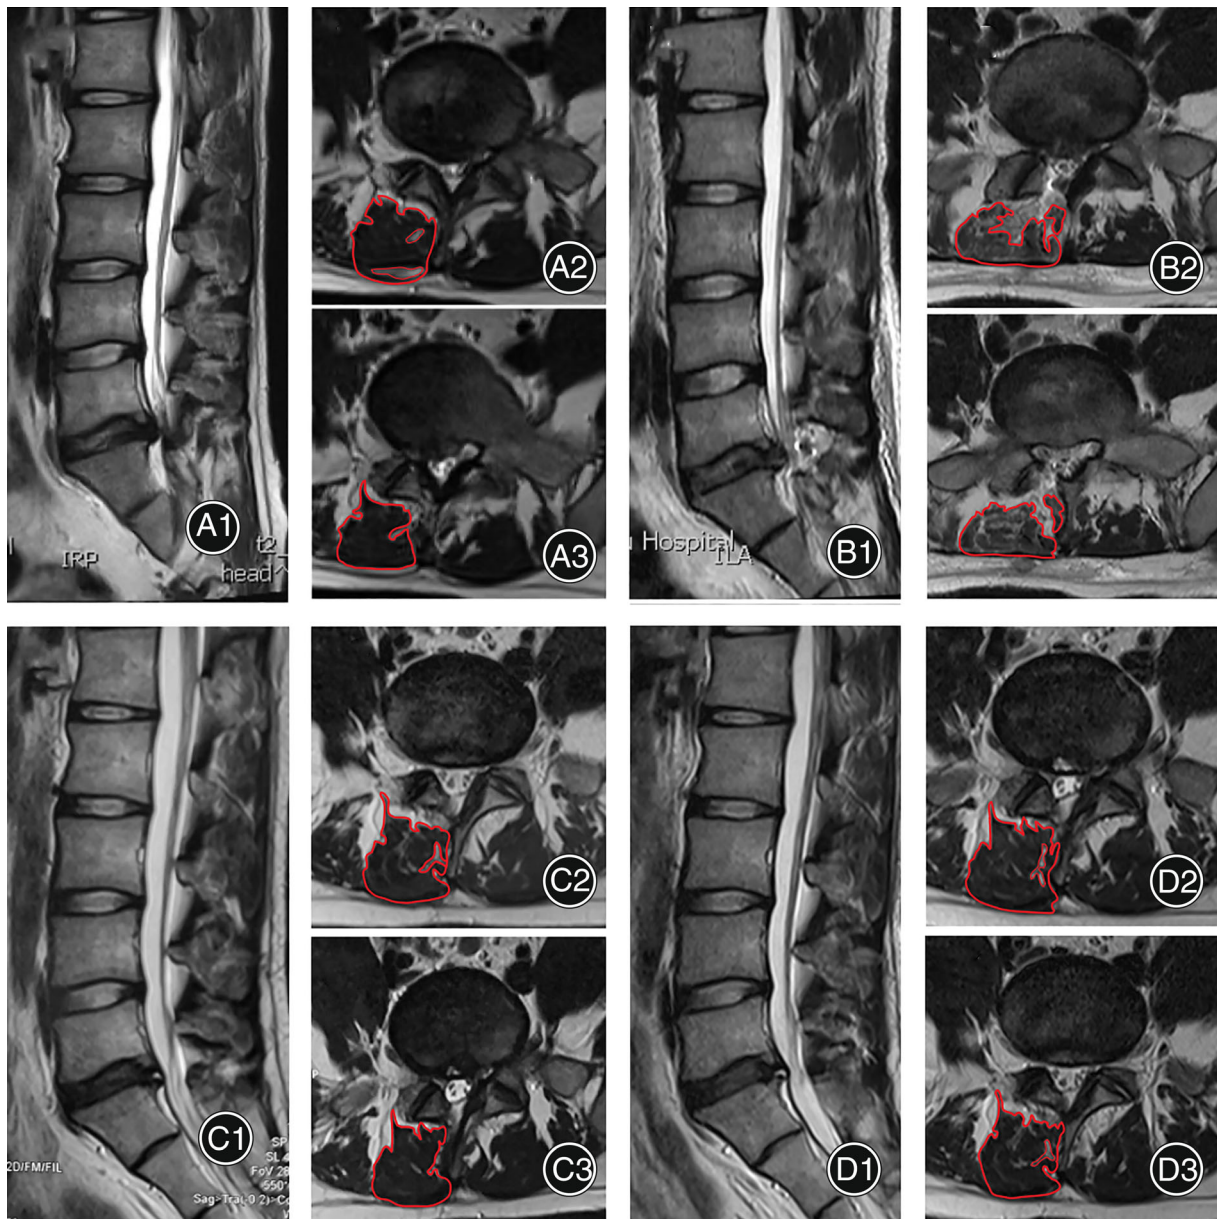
A 23-year-old male patient with LDH of L5/S1 right side, treated with UBED surgery. A1-A3 were the preoperative MRI. B1-B3 were the MRI of post-operative 1st day. C1-C3 were the MRI at the 3-month follow-up. D1-D3 were the MRI at the last follow-up of 1-year. The figures showed that the protruded disc of L5/S1 right side was removed after UBED surgery and the changes of LMCSA during the follow-up. The LMCSA was outlined on preoperative and postoperative MRI image. LDH, lumbar disc herniation; MRI, magnetic resonance imaging; UBED, unilateral biportal endoscopic discectomy.
